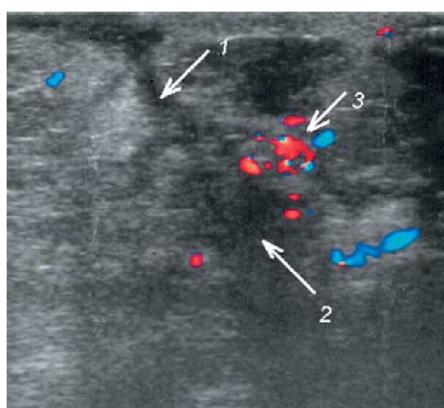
Ultrasound scan. Inflammatory infiltration (color Doppler mode). 1 - sinus tract, 2 - inflammatory infiltrate with a cavity, 3 - increased blood flow spectrum.
